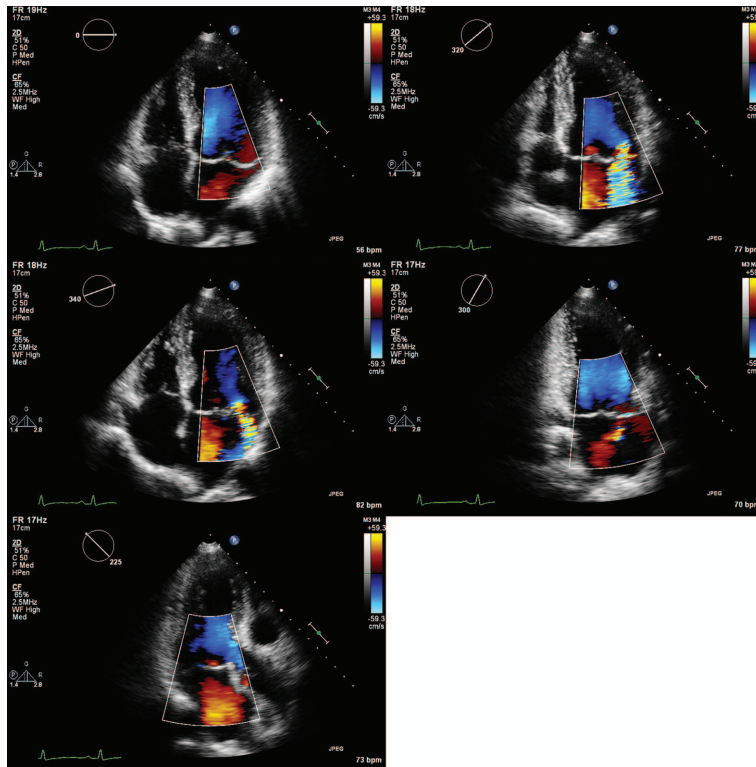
Mitral regurgitation. iRotate: the maximal vena contracta and proximal isovelocity surface area of mitral regurgitation can be easily seen in non-standard 2D cross-sections at 320° and 340° as opposed to the standard cross-sections at 0° (apical four chambers), 300° (apical two chambers), and 225° (apical three chambers).
